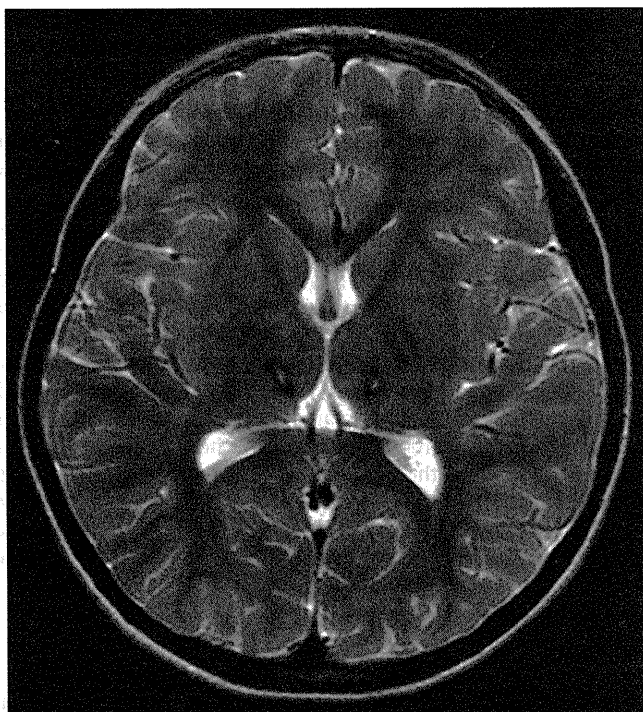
Cranial magnetic resonance imaging at about 6 months after the onset of acute necrotizing encephalopathy. Axial T₂-weighted magnetic resonance imaging reveals a small, high-intensity area indicating the deposition of hemosiderin at the center of the thalamus bilaterally, with no atrophy.
